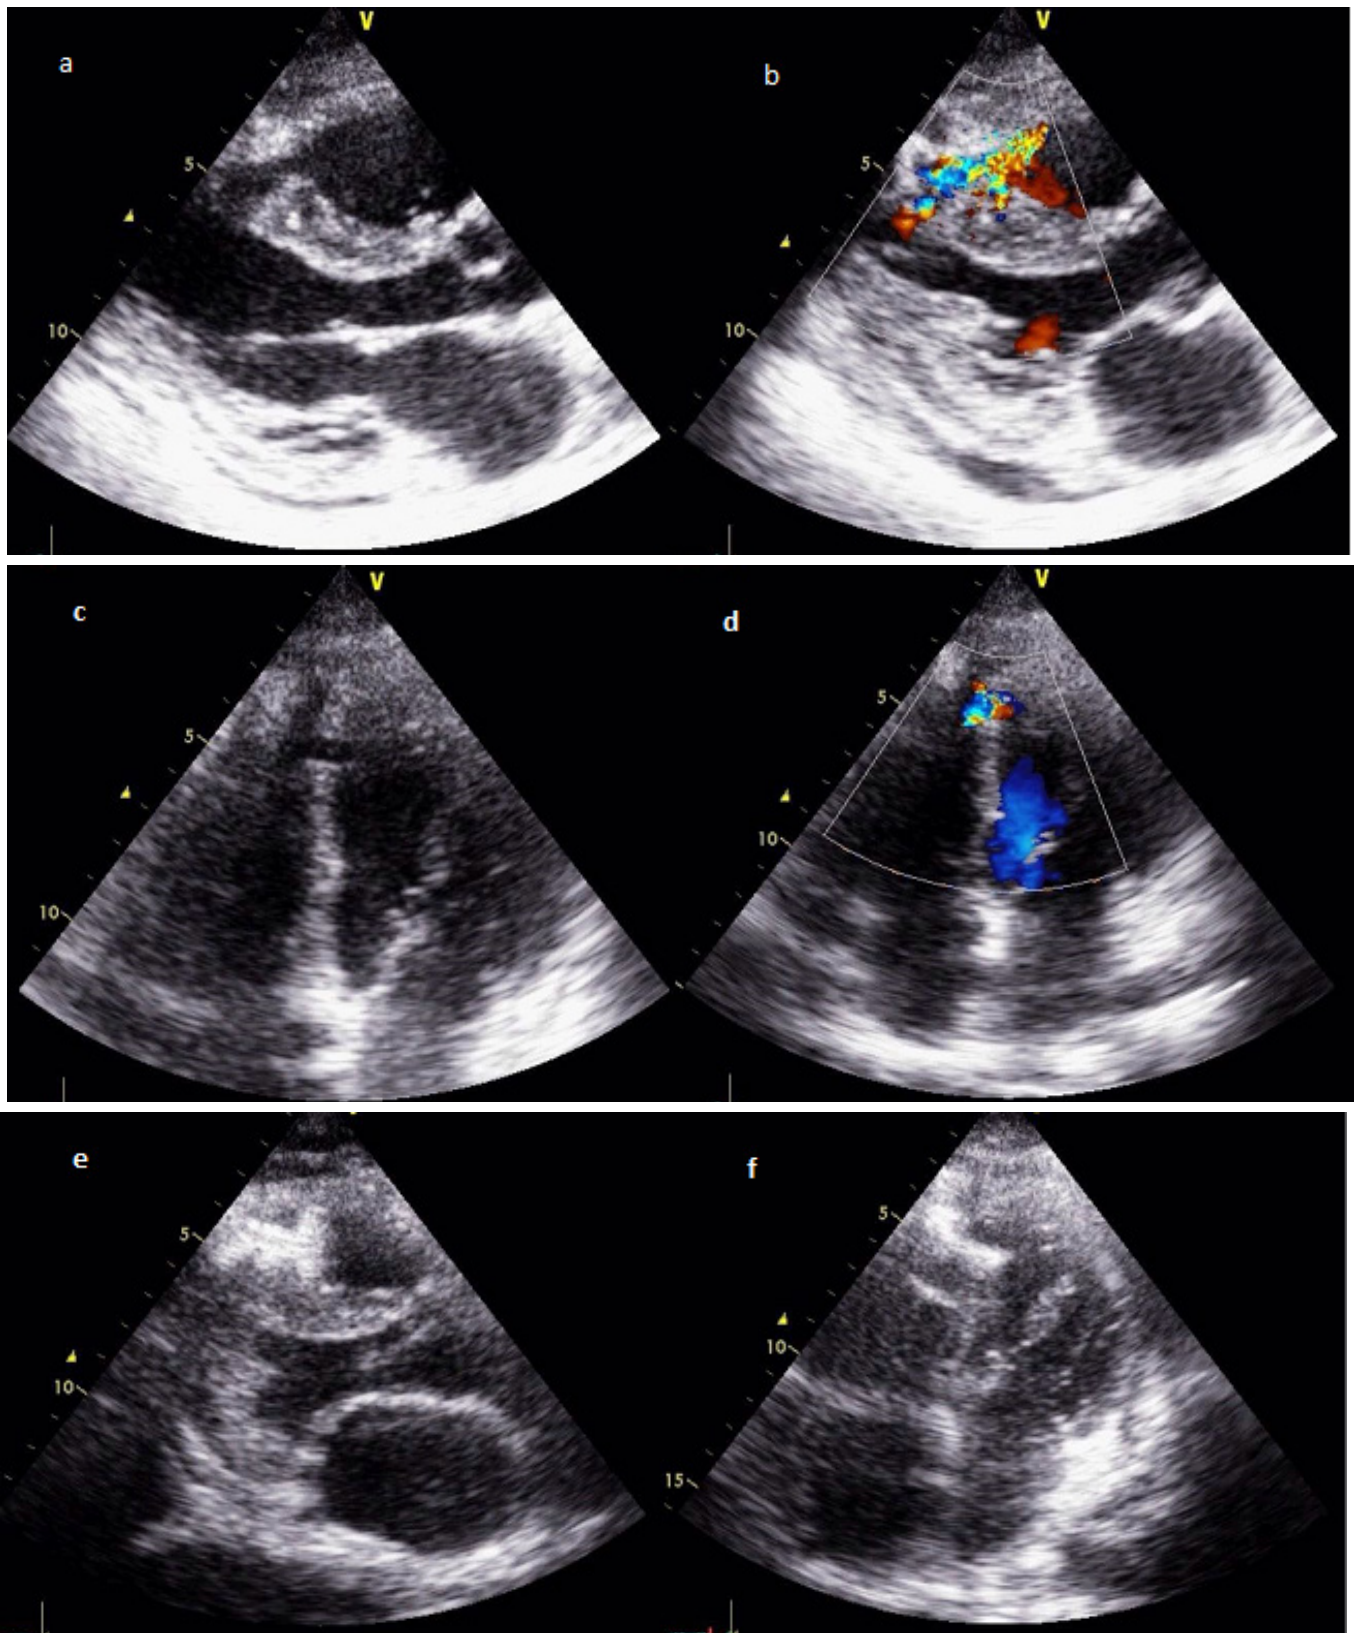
Transthoracic echocardiography, parasternal view showing interventricular traumatic defect in the median septum (a), and evidence of left-to-right shunt (b). Transthoracic echocardiography, apical view of iatrogenic interventricular defect (c) and color-doppler image of the L-R shunt (d). Transthoracic echocardiography, longitudinal view of the successful implanting Amplatzer device to close the tVSD (e-f).
